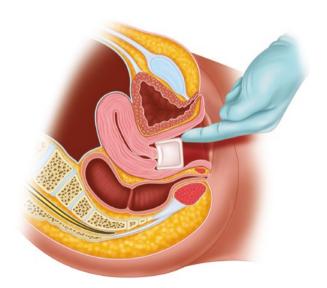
Proper position of the Milex® Regula pessary (CooperSurgical, Trumbull, CT)
